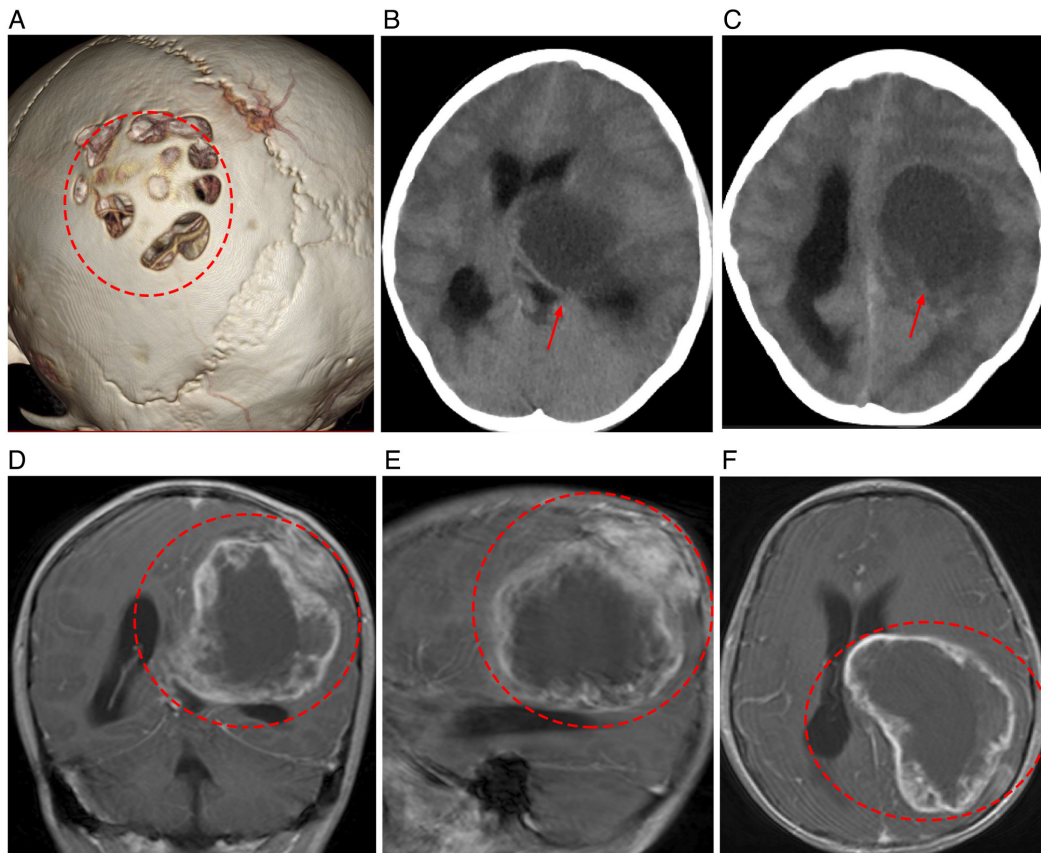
Preoperative cranial imaging. (A) Cranial CT showed resorptive bone loss in the left parietal bone (processed by 3D Slicer 5.7.1; <https://slicer.org>). (B-F) MRI imaging was performed. (B) A large space-occupying lesion is observed in the left parietal lobe, with associated compression of the contralateral ventricle. (C) The lesion results in significant distortion of the surrounding brain tissues and a rightward shift of the midline structures. (D) Coronal view showing a lesion predominantly in the left temporo-parieto-occipital region, with the parietal lobe as the main site. (E) Sagittal view revealing peripheral enhancement and compression of adjacent sulci and ventricles. (F) Axial view demonstrating the mass. Red arrows and circles indicate the precise location of the mass.
